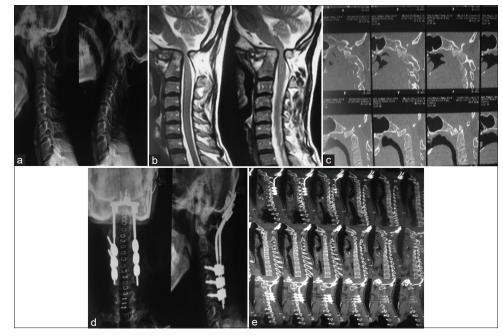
(a) Showing anteroposterior and lateral X-ray of a patient with occipitocervical instability (atlantoaxial dislocation). (b) Showing magnetic resonance imaging scans with cord compression. (c) Showing preoperative computed tomography scan images. (d) Showing postoperative X-ray treated with occipitocervical fusion. (e) Showing postoperative computed tonography scan with fusion
